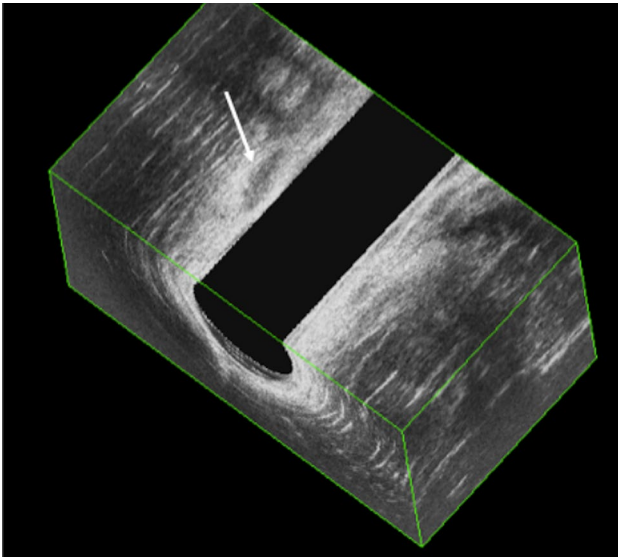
Tridimensional endoanal ultrasound of a female patient complaining for both anal incontinence and dyskinetic evacuation showing the loss of integrity of the internal sphincters related to the previous surgery. Note the asymmetry of the internal sphincter, with residual portions on the right side (straight arrow) and the inhomogeneity of the external sphincter
